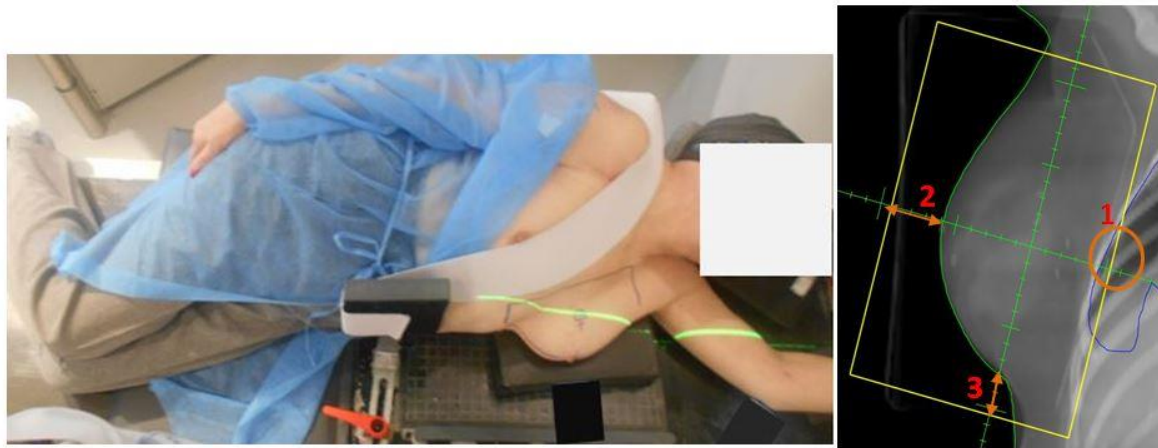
Patient position with the DLI technique and the three distances D1, D2, D3 measured on the Digital Reconstructed Radiographs DRR
